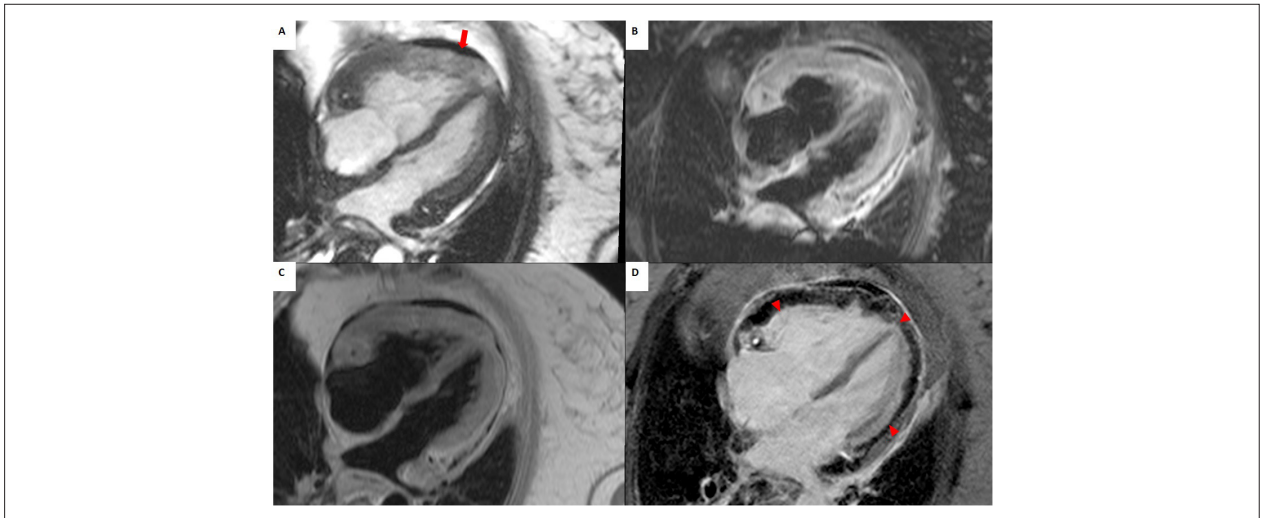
a) Steady -state free precession (SSFP)-cine imaging showing an ill-defined, heterogeneous myocardial mass involving all cardiac chambers, particularly the right ventricle wall and right atrioventricular groove, as well as moderate pericardial effusion (solid arrow). b) T2-weighted magnetic resonance imaging showing hyperenhancement of the mass, compatible with edema. c) T1-weighted sequence showing isointensity of the heterogeneous mass. d) T1-weighted inversion recovery showing late gadolinium enhancement of the myocardium (compatible with myocardial fibrosis) and hypoenhancement of the mass, marking the limit between myocardium and tumor (arrowheads).
